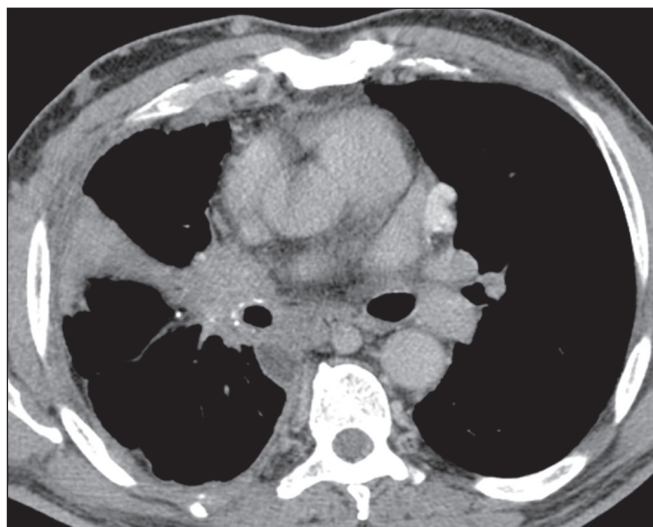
CT of a 51-year-old woman with fibrosing mediastinitis. Histoplasmosis was not identified on the biopsy but was diagnosed by immunodiffusion. Note the infiltrative lesion in the subcarinal and hilar lymph nodes on the right, containing foci of calcification, as well as the atelectasis in the middle lobe.
